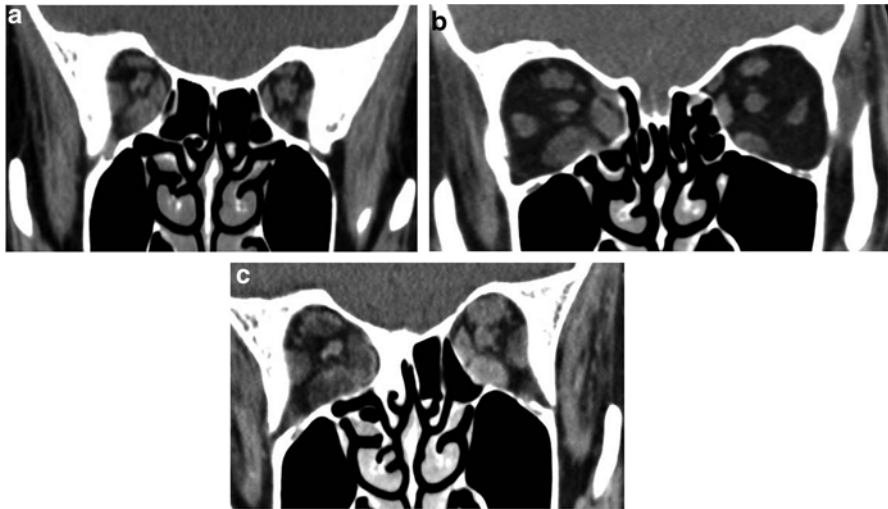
(a) A 65-year-old male with progressive onset of right visual deterioration with right compressive optic neuropathy. (b) Immediately following decompression, his right color and central vision improved. The medial floor and wall have been expanded into the adjoining sinuses, reducing compression on the central optic nerve. (c) Five years later he developed a sudden onset of left congestive features with a drop in color and central vision. CT Scan shows interval enlargement of the left extraocular muscles with optic nerve crowding; the contrast enhancement suggests active inflammation in the muscle. The right muscles remain enlarged but the clear zones represent hyaluronic acid deposition and are typical in longstanding quiescent disease. He was treated successfully with left orbital decompression and adjuvant steroid/radiotherapy
